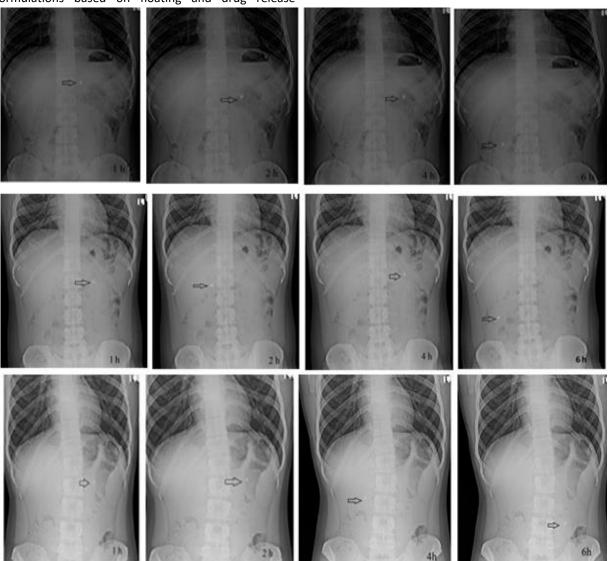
In vivo X-ray study of BaSO₄ loaded floating mini tablet (CEP13)
